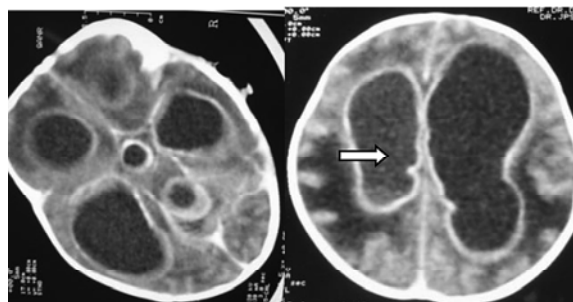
Contrast CT brain showing enhancement of ependymal lining of ventricles suggestive of ventriculitis
